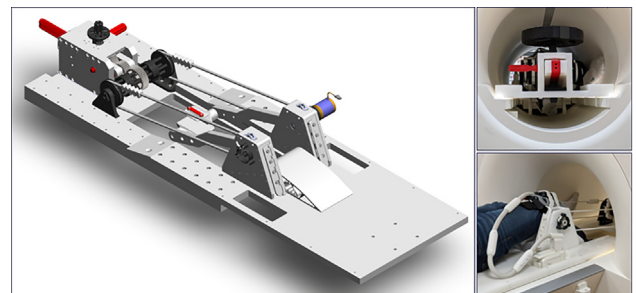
Three-dimensional rendering of the MRI knee motion device (left) and pictures of the device in the scanner (right).
